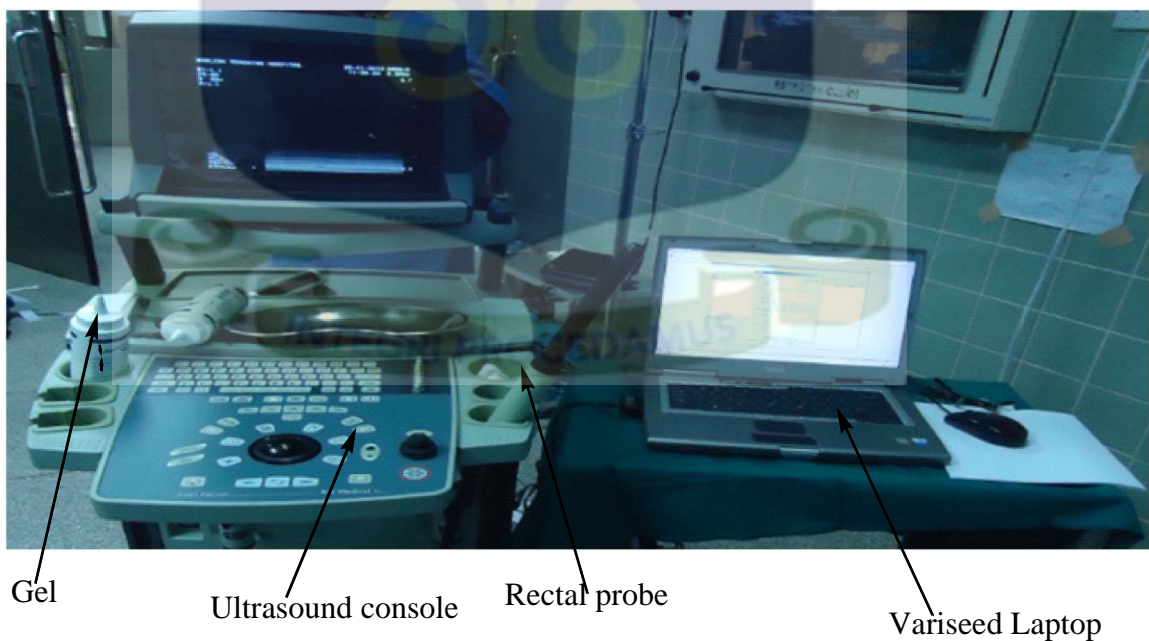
A pictorial view of ultrasound unit, rectal probe, Gel and a Variseed computer used at the theatre of Korle-Bu Teaching Hospital during real-time implant.
